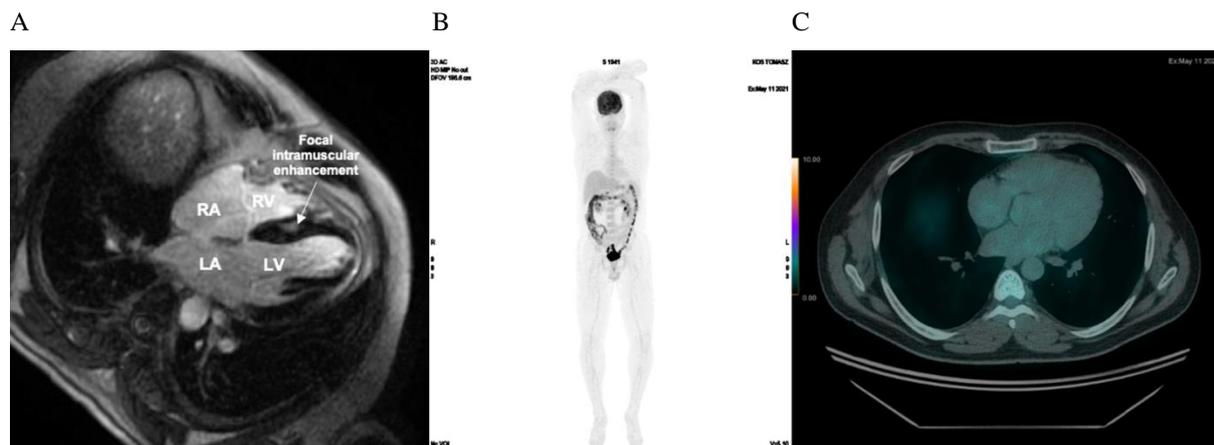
A – cardiac magnetic resonance, four chamber view: RA – right atrium, LA – left atrium, LV – left ventricular, RV – right ventricular; B, C – ^{18}F -FDG-PET/CT: no active foci of increased ^{18}F -FDG uptake were found, presence of active disease process in heart and other parts of body was excluded.
